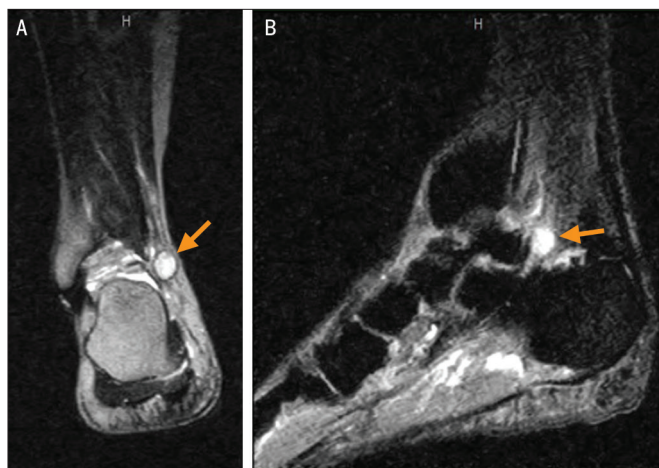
(A) Coronal, T2-weighted, fast spin-echo magnetic resonance image of the ankle showing the nerve tumor (arrow). (B) Sagittal, short-tau inversion recovery magnetic resonance image showing the nerve tumor (arrow).
